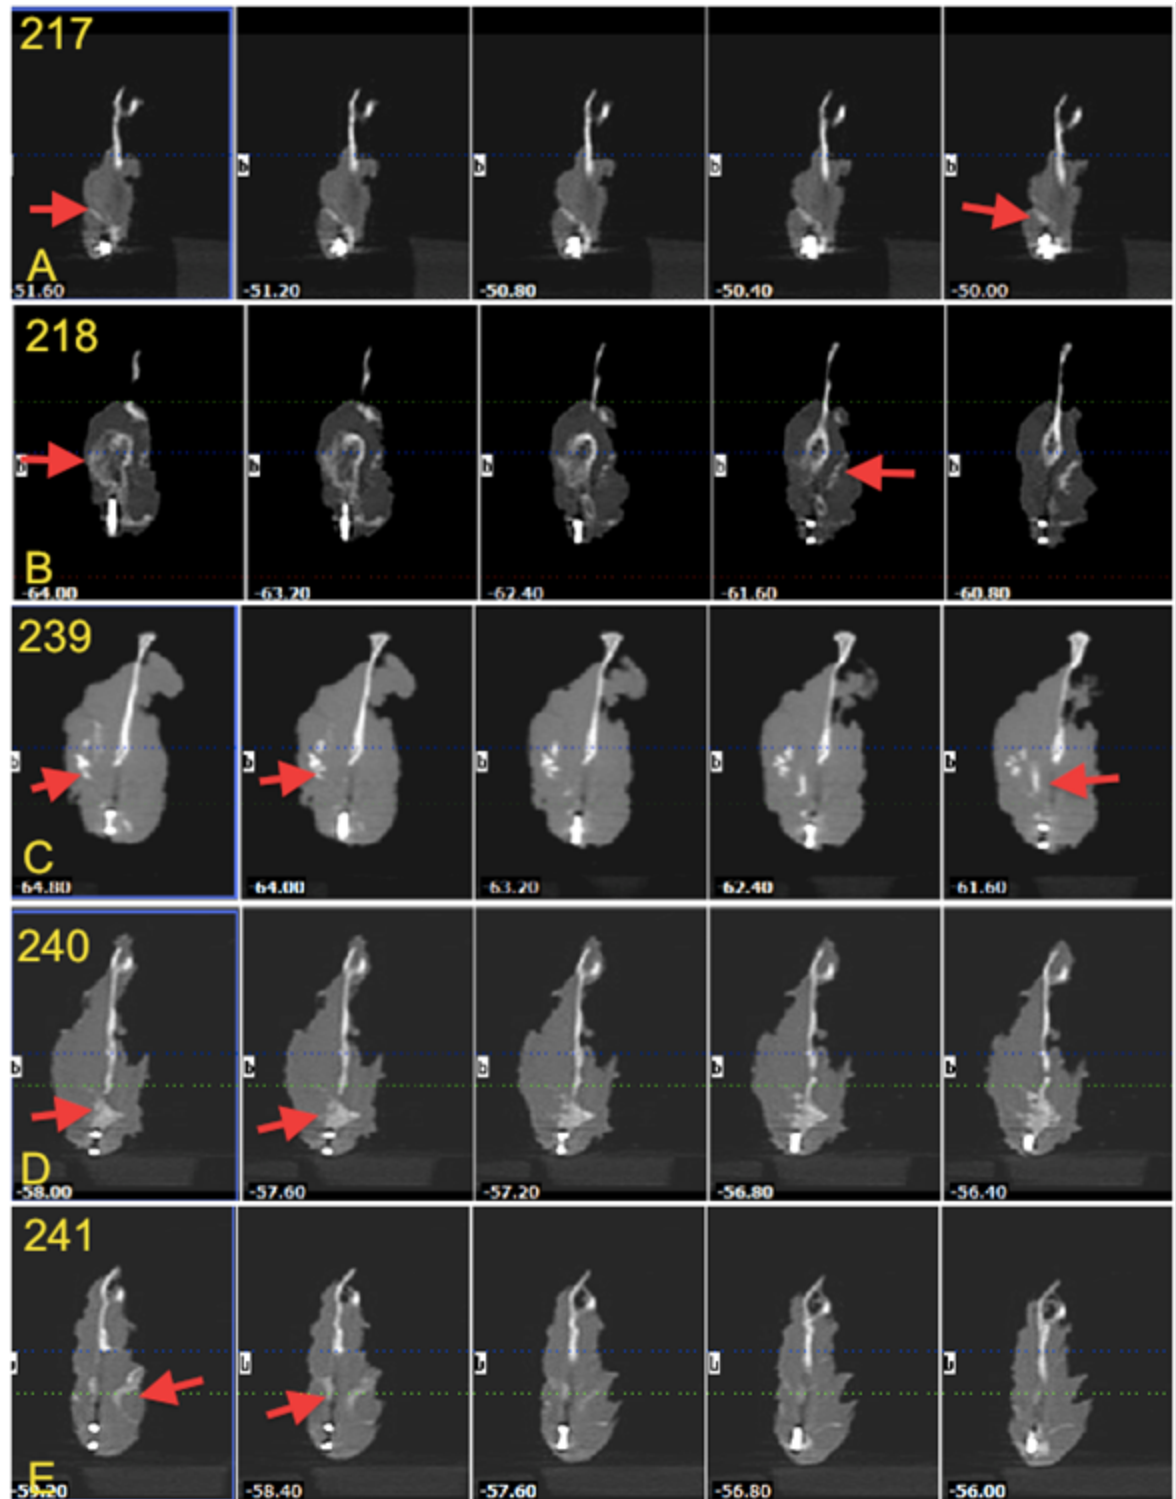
b: Consecutive CBCT coronal images for all cases involved in the main study, A) shows case 217, the radio-opaque tissue was located only inferiorly and directed laterally, B) shows case 218, radio-opaque tissue was located lateral to the defect and displaced, expansion of both cortices is denoted with red arrows, C) shows case 239, radio-opacity was sporadically located lateral to the defect area (arrow), D) shows case 240, with radio-opacity that appears continuous from the superior to the inferior border that was wider medio-laterally (arrow), E) Case 241, sporadic areas of radio-opacity are located at the centre and medial side of the defect (arrow)
